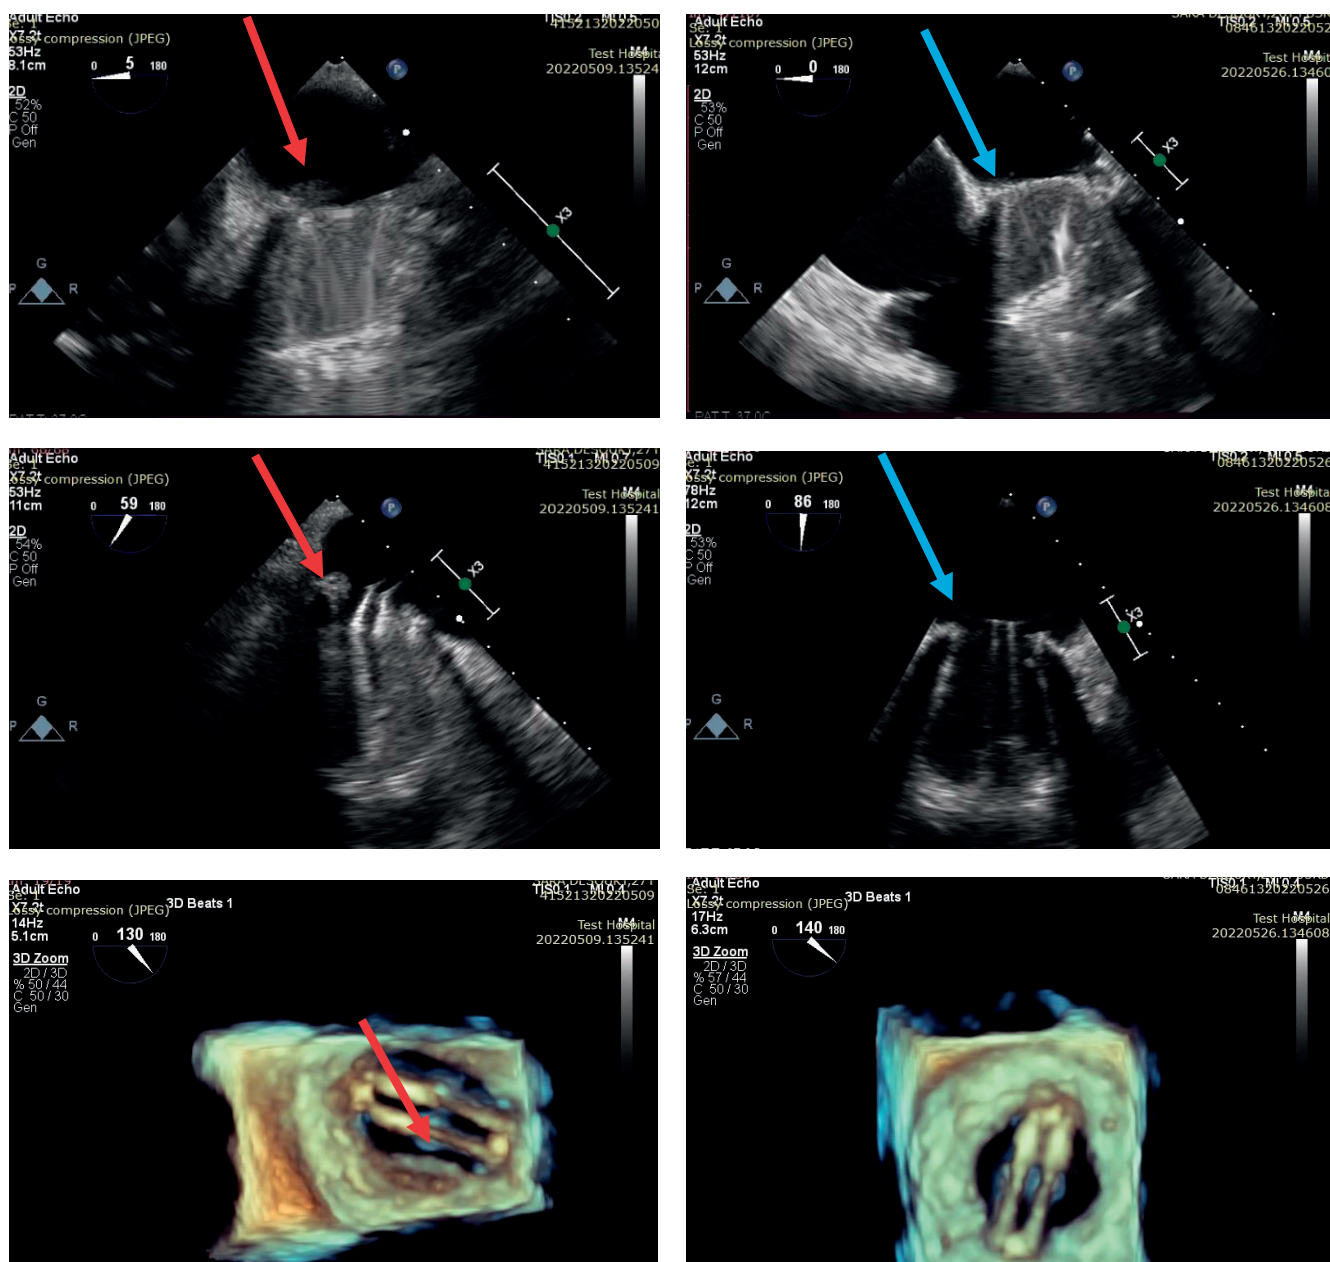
Transoesophageal images. Left panel images showed thrombus (red arrows) related to one of the occluder of mitral mechanical prosthesis. Right panel images showed follow-up transoesophageal echocardiography images revealing resolution of the thrombus (blue arrows) after anticoagulation therapy
